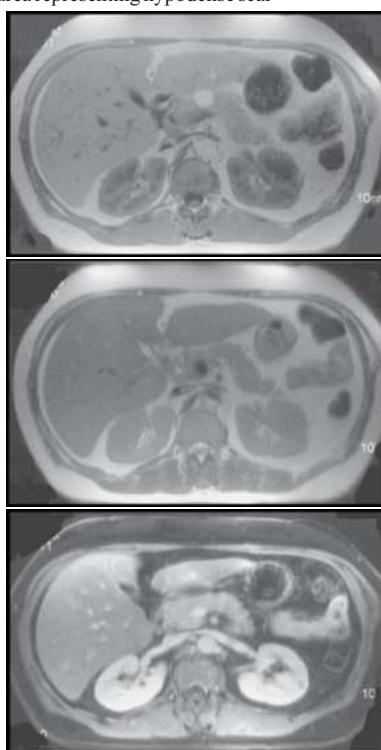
Normal renal MRI. A T1-weighted (gradient opposed-phase) image (A) and a T2-weighted axial image (B) demonstrate the normal appearance of the kidneys. (C) T1-weighted axial gadolinium-enhanced image reveals normal enhancing renal parenchyma. Renal vein and renal artery are also seen.
